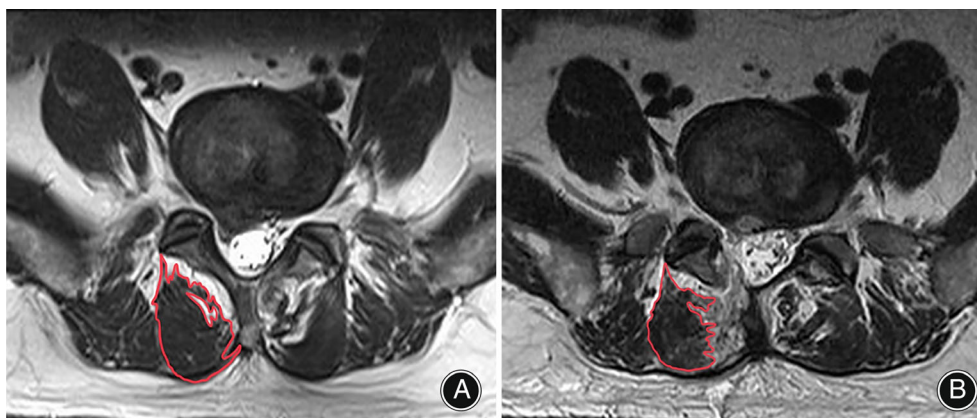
The preoperative (A) and postoperative (B) measurement of LMCSA on MRI. The middle cross-sectional image of the operative disc was selected on T2-weighted MRI. The contour of multifidus at the operative disc was outlined by irregular curve on the MRI image, and the area was calculated by the ImageJ software. The change rate of LMCSA is calculated as $= (\text{preoperative LMCSA} - \text{postoperative LMCSA}) / \text{preoperative LMCSA} \times 100\%$. LMCSA, lean multifidus cross sectional area; MRI, magnetic resonance imaging.
